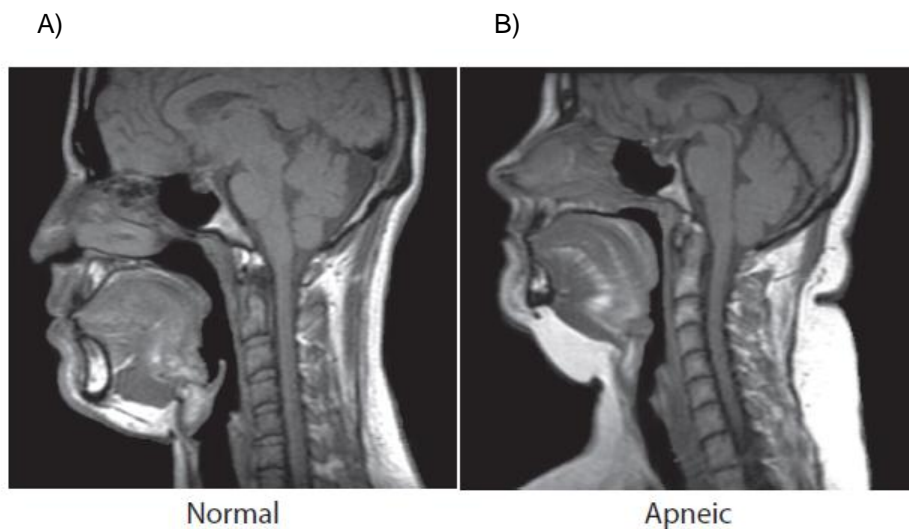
Magnetic resonance imaging (MRI) of the upper airway of a) a normal individual and b) a typical sleep apnea patient. The decreased size of the upper airway due to obesity and narrower upper airway anatomy is clear (e.g. larger tongue and smaller mandible). Fat is shown in white. Reproduced from a) Schwab *et al.* 2005¹⁴ and b) from Schwab, personal files.
